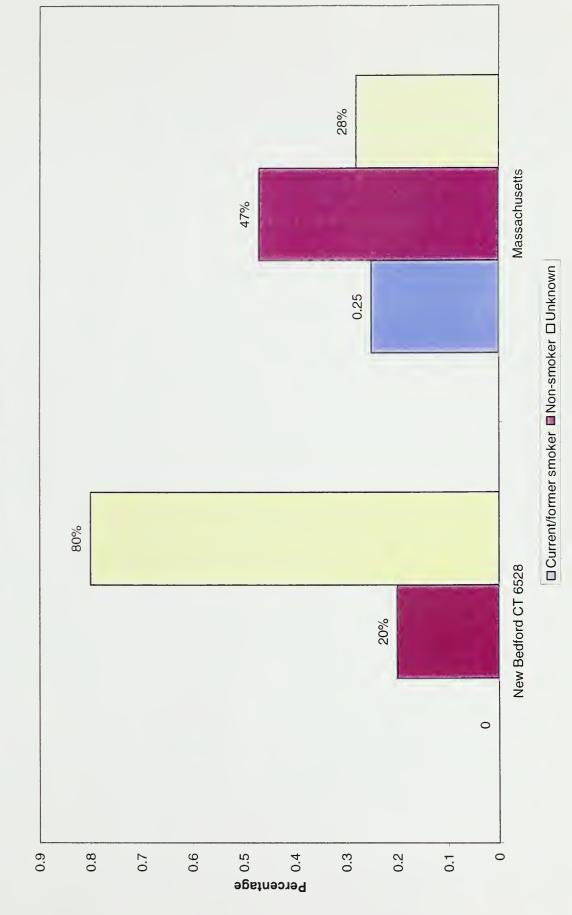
Smoking Status of Males with Kidney Cancer in New Bedford CT 6528 and Massachusetts, 1995-1998
